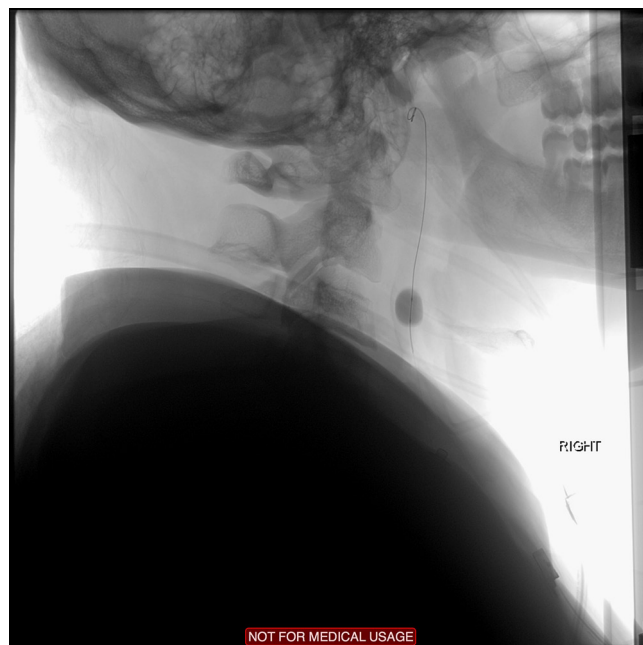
Single-shot radiograph of 7×7 mm balloon after having been pulled down to the carotid bifurcation. At this point, the balloon is slightly hyperinflated beyond the vessel diameter to propel clot into the ECA.
